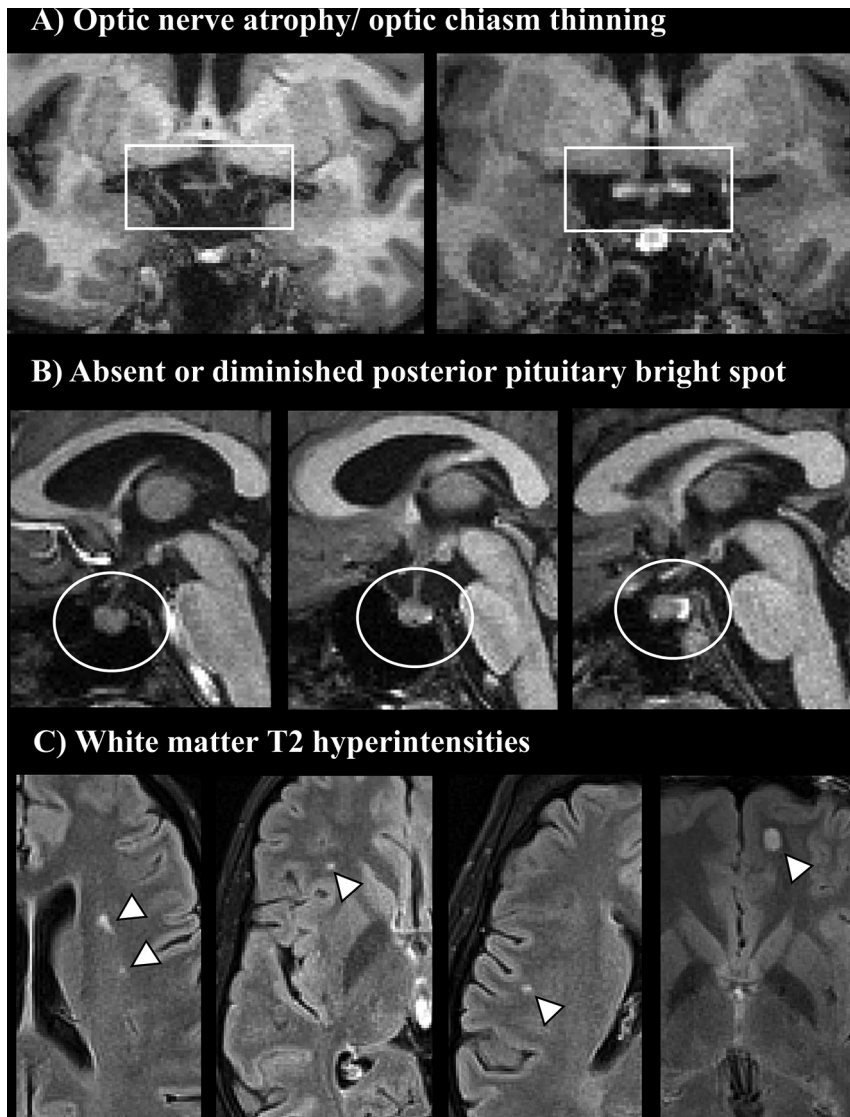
Examples of neuroradiologic findings in patients with Wolfram syndrome. A, Thinning of the optic chiasm (*white box*) as seen in coronal T1-weighted images (*left*, patient with Wolfram syndrome; *right*, healthy control). B, Abnormal PPBS signal (*white circles*) in midline sagittal T1-weighted images (*from left to right*, absent, diminished, and physiologic signal). C, White matter hyperintensities in FLAIR MR imaging (*white arrowheads*).
